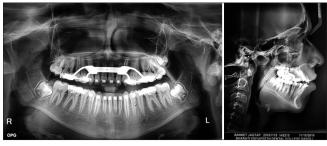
Progress radiographs
